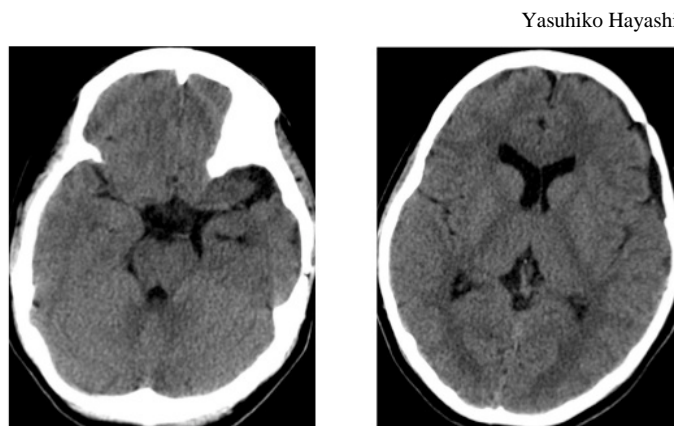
A CT scan of the head obtained 6 months after the operation showed a remarkably reduced arachnoid cyst and a completely diminished subdural hematoma.
